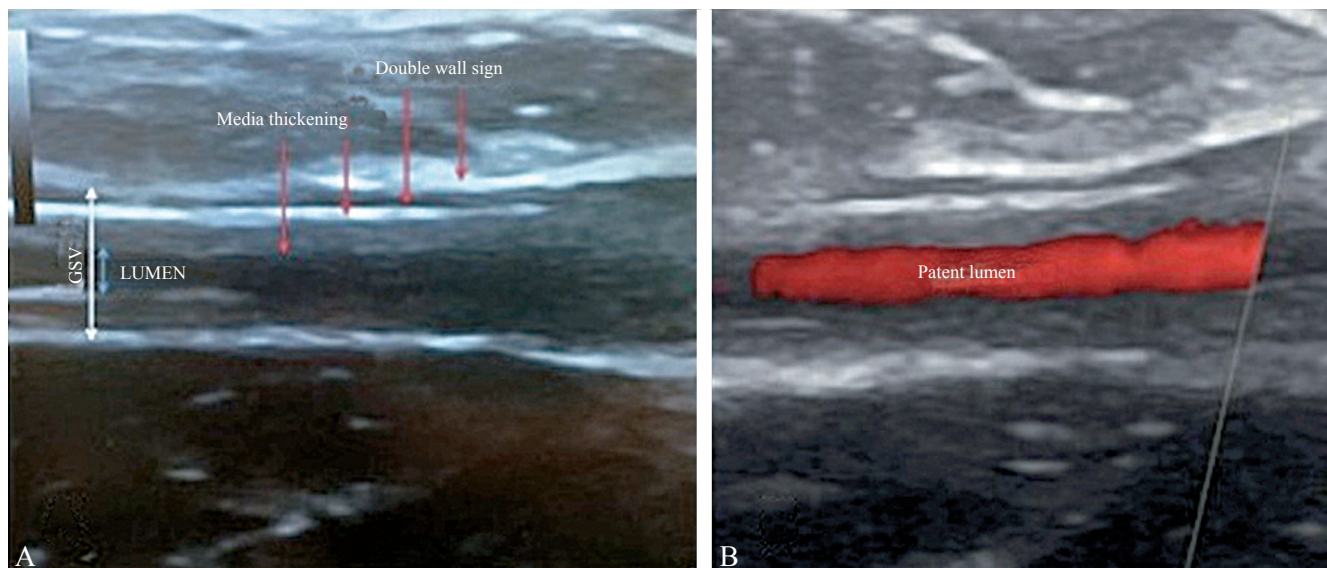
A Venous wall thickening after HL shrinkage. A “double wall sign” is created by the appearance of the adventitia and the hyperechogenic line that is produced after HL use. A narrower but still patent lumen is clearly evident by color-Doppler investigation (B).
